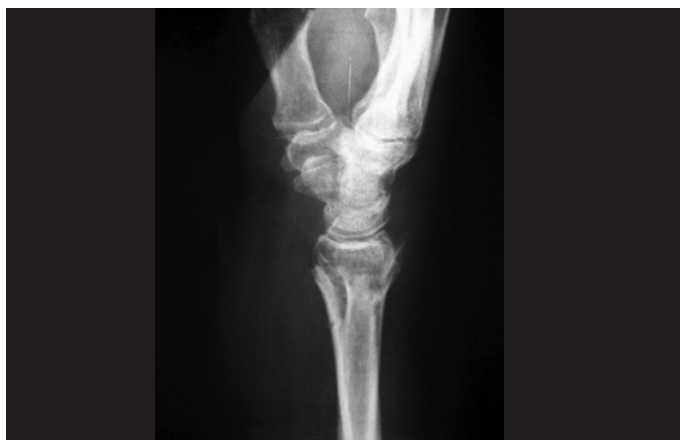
Radiograph on wrist in lateral view after removal of the synthesis material, showing correction of the volar angulation of the distal radius.
